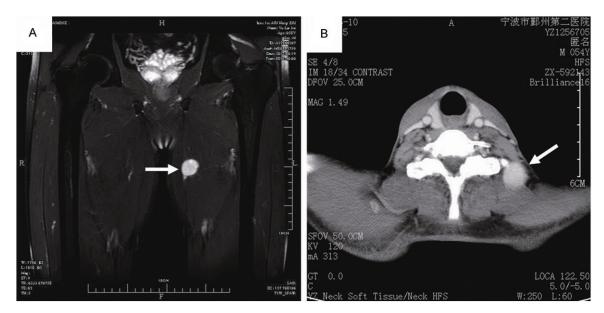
Imaging features of angiofibroma of soft tissue. A. Contrast-enhanced magnetic resonance imaging scan of case 1 showed a well-defined ovoid soft tissue, hyperintense to muscle, located deep to the musculus gracilis of the left thigh. B. Contrast-enhanced computed tomography scan of case 2 revealed a homogeneously enhancing, well-defined, firm soft tissue mass located in the left posterior neck region between the first and second intercostal space.
